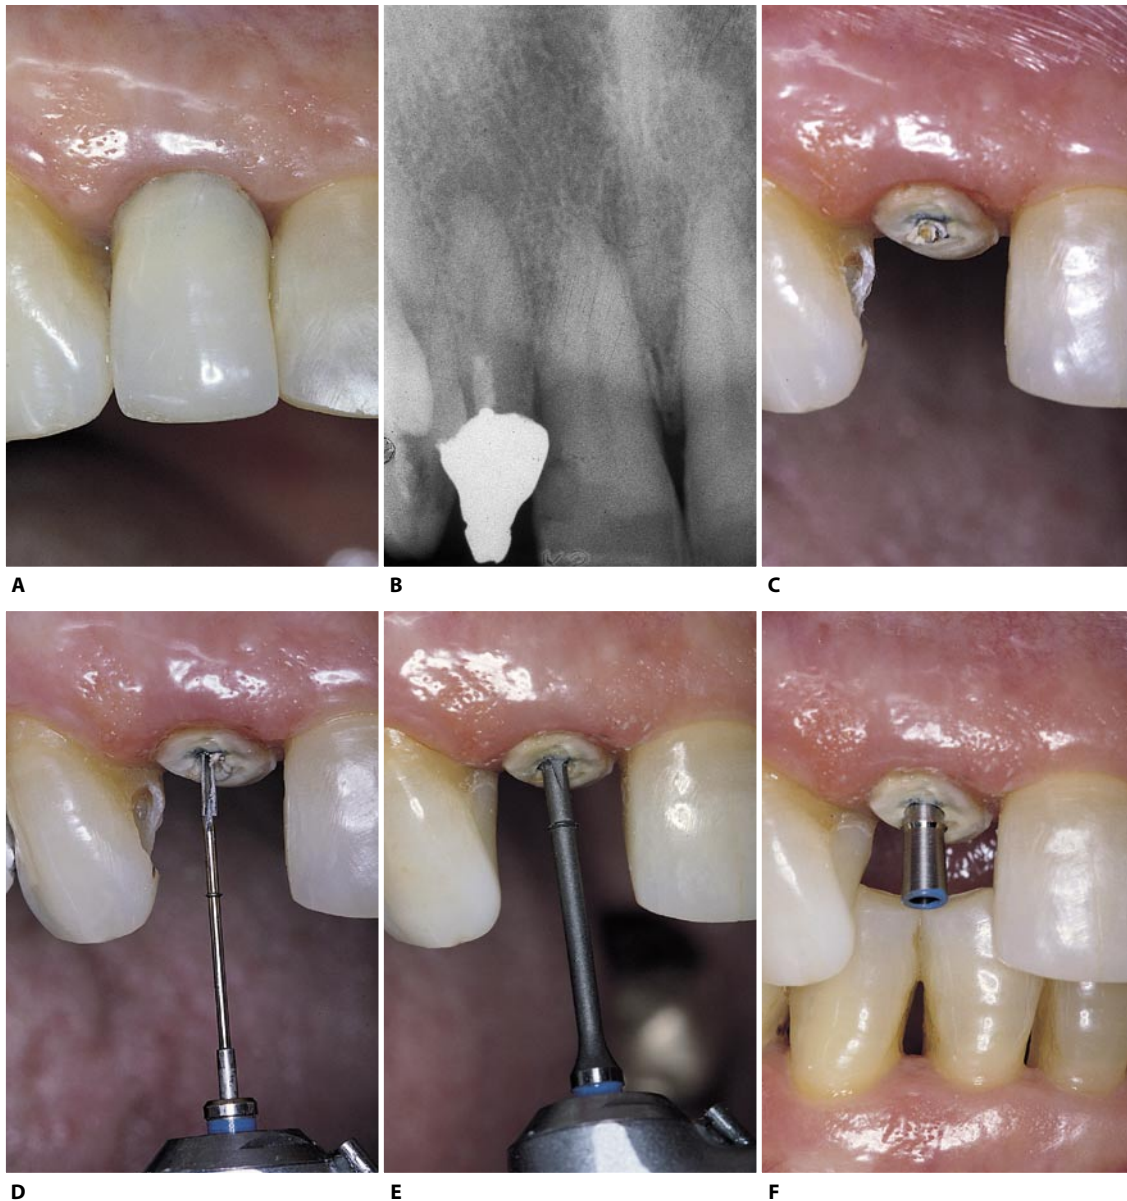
Clinical (A) and radiographic (B) appearance of an upper right lateral incisor that requires endodontic retreatment after the removal of the existing prosthetic restoration. C. With the use of ultrasound, the crown has been removed, and the root have been regularized and cleaned of carious tissue. D, E. The coronal one third of the root canal is widened with calibrated burs. F. The hollow post is tried in place, checking that there is no interference in maximal intercuspitation (continued).
